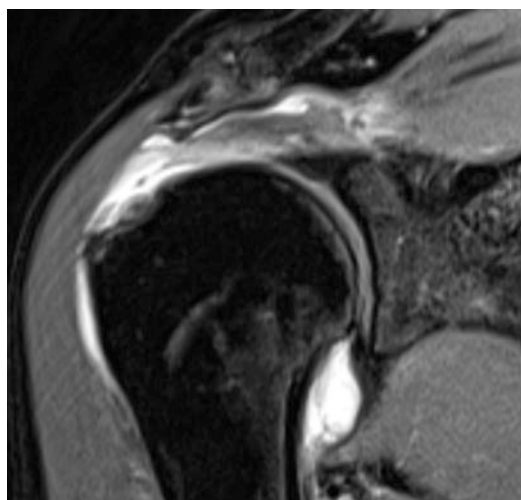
MRI in coronal plane showing full-thickness tear of supraspinatus tendon without marked retraction
